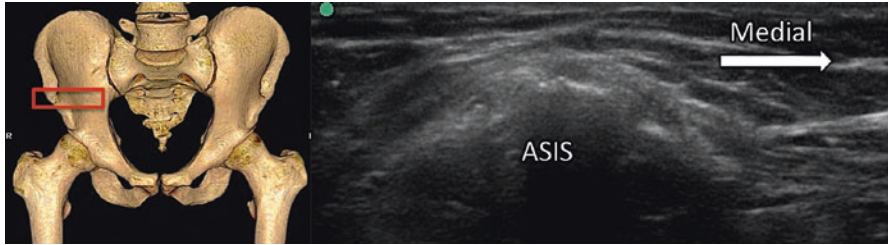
Sonographic image of the anterior superior iliac spine (ASIS). (Reprinted with permission from Philip Peng Educational Series)
